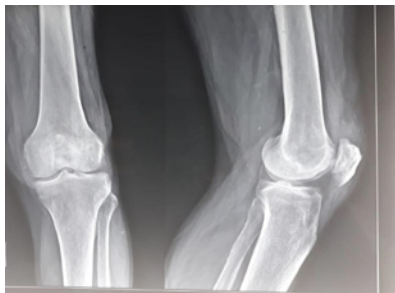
Standard radiography of the knee from the front and in profile objectivize a low patella with indirect signs of quadriceps tendon fracture at the insertion at the upper edge of the patella.
